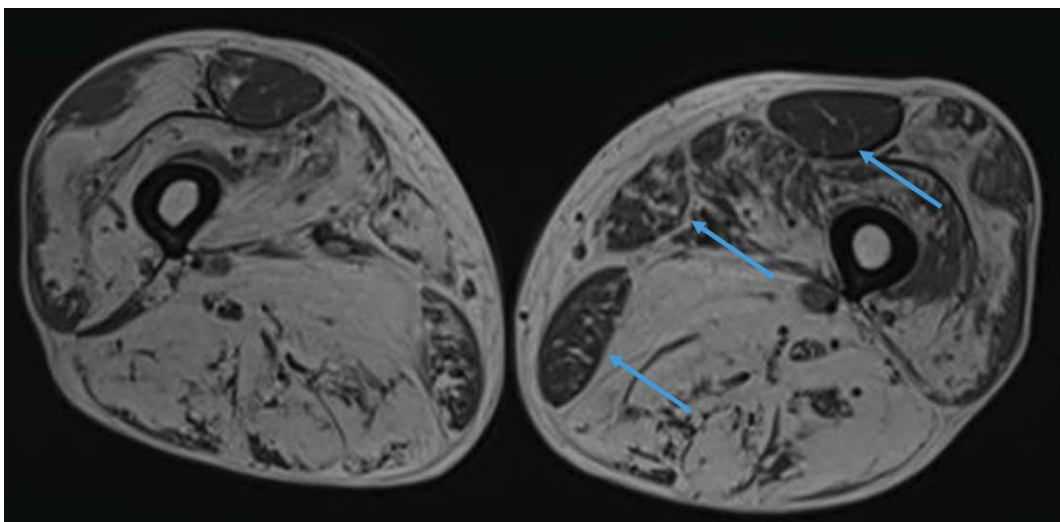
Lower limb MRI. Major fatty replacement of the thigh muscles with partial sparing of the adductor muscle, the *rectus femoris* and the *gracilis* muscles (arrows).
